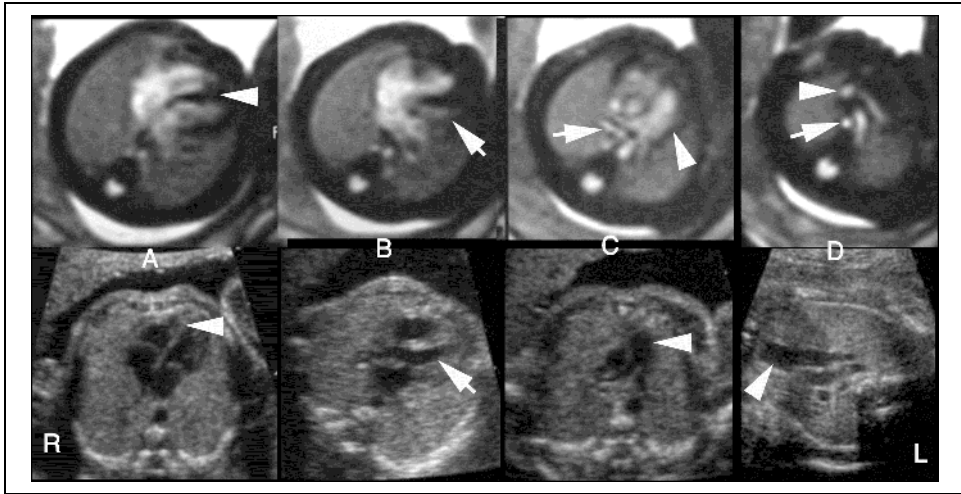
Comparable axial anatomy of the fetal heart (at 26 weeks' gestation) in MRI (upper row) and echocardiography (lower row) from caudad to cephalad; R: right, L: left. (A) Four-cardiac-chamber view: arrowheads point to interventricular septum. (B) Left ventricular outflow tract (LVOT) view: arrows point to (LVOT). (C) Right ventricular outflow tract (RVOT) view: arrowheads point to the bifurcating main pulmonary artery; arrow in upper MR image points to the right main bronchus posterior to the right pulmonary artery. (D) Three-vessel-view: arrowheads point to the right brachiocephalic vein which meets its left counterpart to form superior vena cava (SVC). Aorta winds around the trachea (arrow in upper MR image points to fluid-filled trachea).
